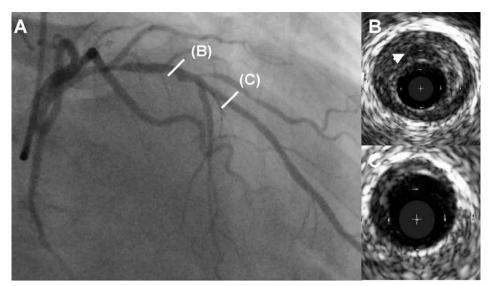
Coronary angiogram (A) of the left anterior descending coronary artery and corresponding intravascular ultrasound (IVUS) images (B and C) of a 55 year old patient presenting with an acute coronary syndrome. In panel B an IVUS frame is provided showing a large plaque area with an echolucent zone (arrowhead) and luminal obstruction, possibly suggesting the presence of a vulnerable plaque. Panel C shows a more distally obtained IVUS frame with minimal plaque burden.
